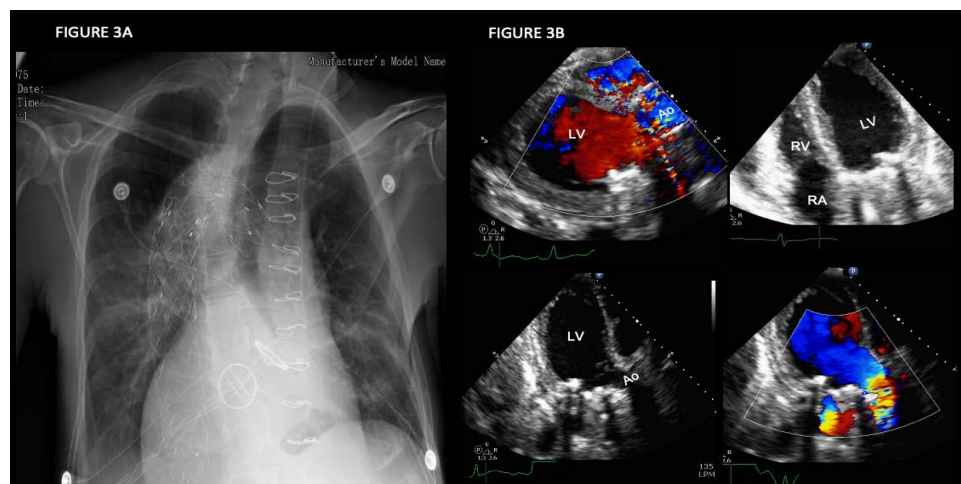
(A) Anteroposterior chest X-ray showing grade II cardiomegaly, endoprosthesis and coronary vascular stents in the ascending and descending thoracic aorta. Mechanical aortic and mitral prosthetic valves. (B) Transthoracic echocardiography. The mechanical mitral (mean gradient 4.9 mmHg, indexed EOA 1.46 cm²/m²) and aortic (mean gradient 3.9 mmHg, indexed EOA 1.46 cm²/m²) prosthetic valves are visualized. Also, left ventricular dilatation and hypertrophy are evident. Abbreviations: Ao: aorta, EOA: Effective orifice area. The other abbreviations as before.
